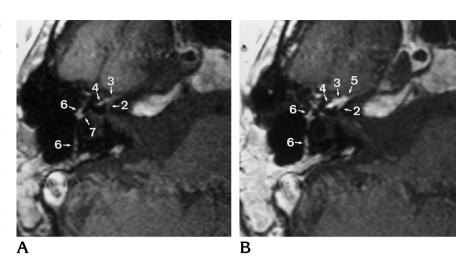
Noncontrast transverse (500/15/2) (A) and contrast-enhanced transverse (B) and coronal (C) T1-weighted (640/21/4) images, obtained 45 days after transverse fracture and immediate-onset palsy, show abnormal enhancement in the distal intrameatal segment (1). The contrast-enhancing fracture line ( $\delta$ ) crosses the vestibule and the thickened proximal tympanic segment (4) of the facial nerve. The cochlea (9) and vestibule (10) show moderate enhancement. The geniculate ganglion (3) is thickened and enhanced.
